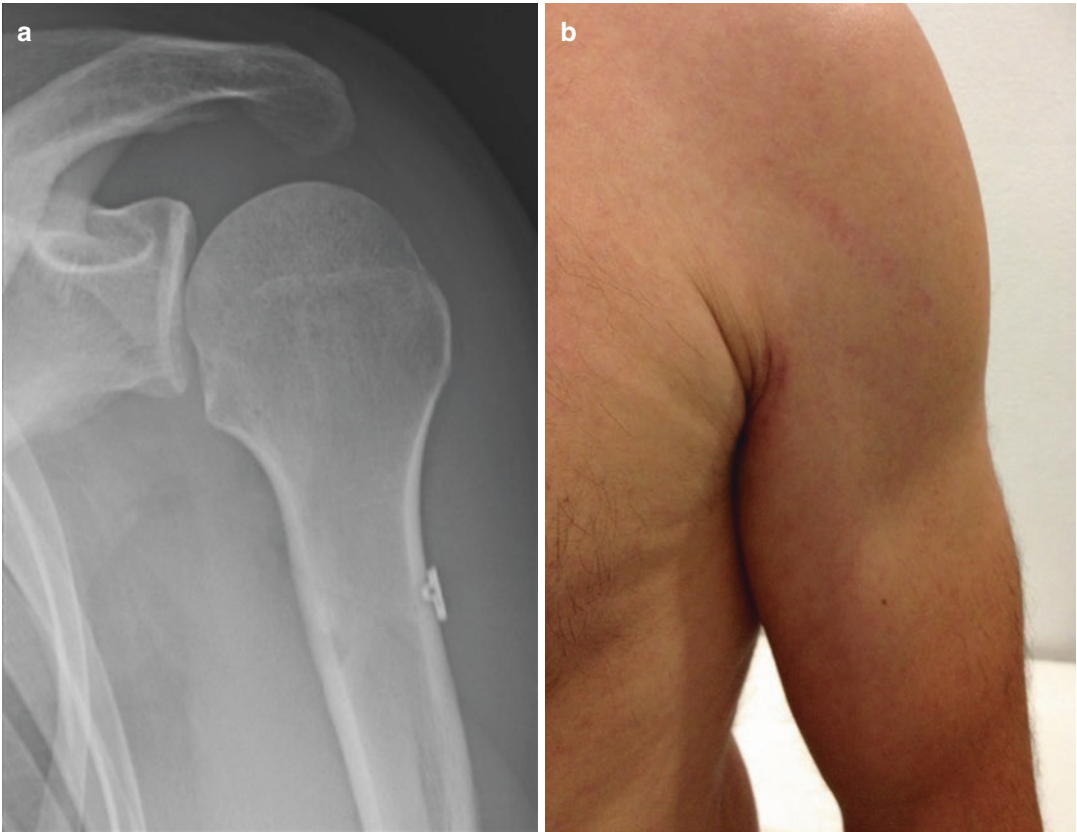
Subpectoral tenodesis and bicortical fixation with a suspensory button. (a) Postoperative X-ray. (b) Postoperative appearance: good cosmesis and no Popeye sign
